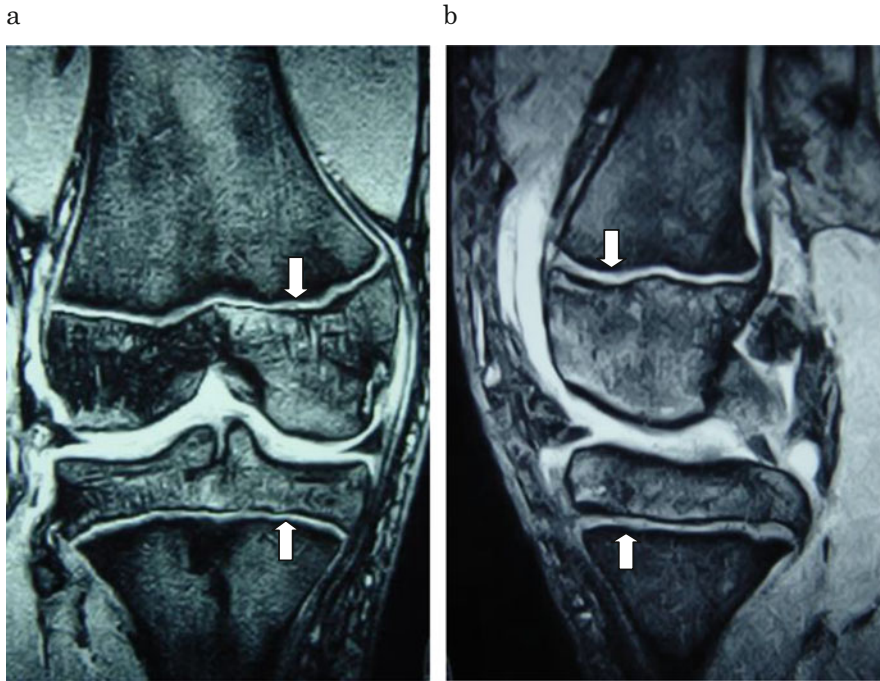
Preoperative T2-gradient-recalled echo MRI of the knee in the coronal plane (a) and the sagittal plane (b). The images show the very high-signal bands of the physes (no drop-out signs) [19]
